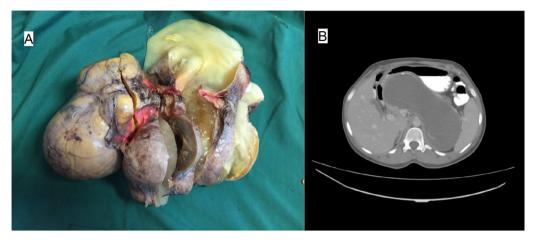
(A) Gross view of the resected tumor showing various tissue types within the mass. (B) Axial view of the CT scan showing a large retroperitoneal tumor posterior to the pancreas and anterior to the left kidney pushingthe stomach and the pancreas forward and compressing on the small bowel loops. The tumor contained calcifications along with heterogeneous cystic lesions measuring 210×154 mm.
